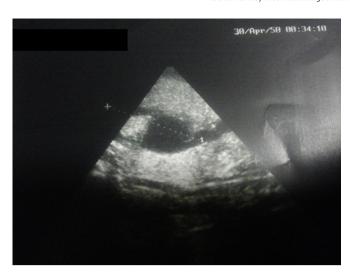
Transabdominal sonography, dilatation of ureters.
